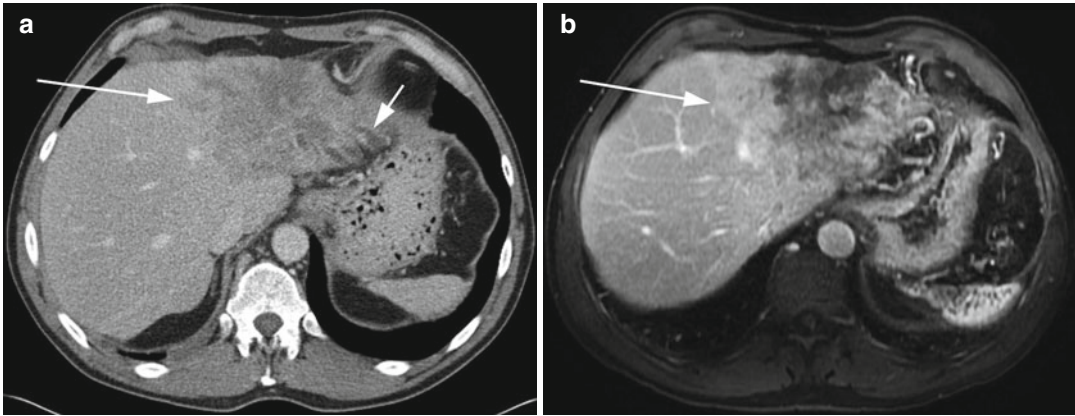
Cholangiocarcinoma in a 52-year-old male with PSC. (a) Portal venous phase CT depicts a large, poorly marginated, heterogeneous intrahepatic mass-forming cholangiocarcinoma (*long arrow*) in the left
